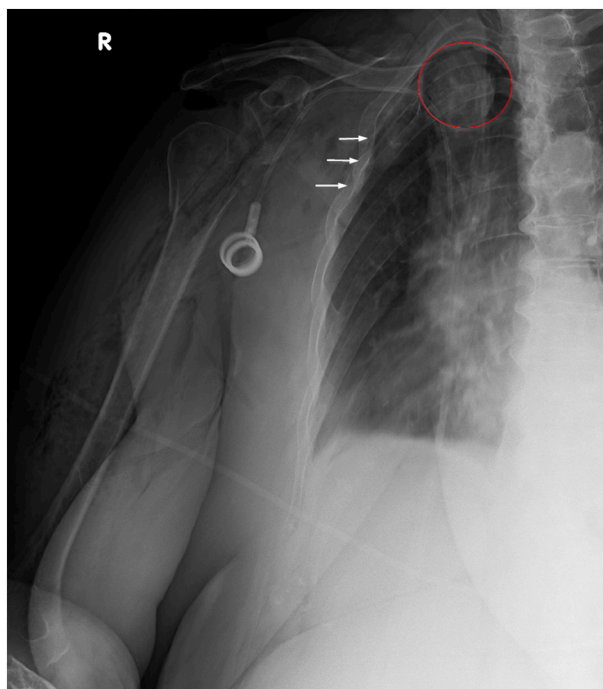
X-ray of the shoulder (white arrows: rib fractures; red circle: humeral head fragment).
